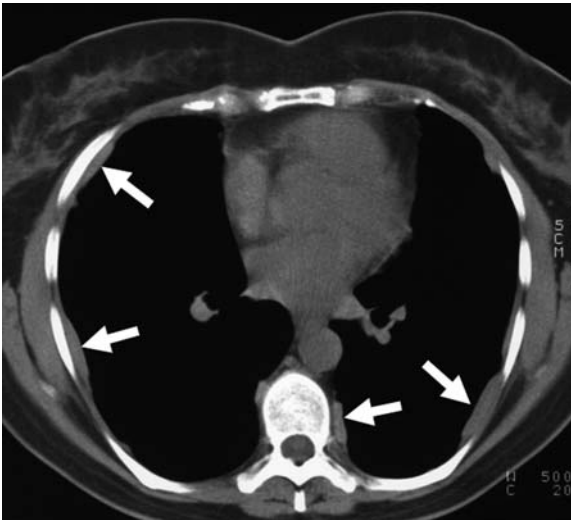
Computed tomography scan of the chest shows extensive anterior-lateral and postero-lateral pleural plaques appearing as smooth lines of soft tissue attenuation (*arrows*)
